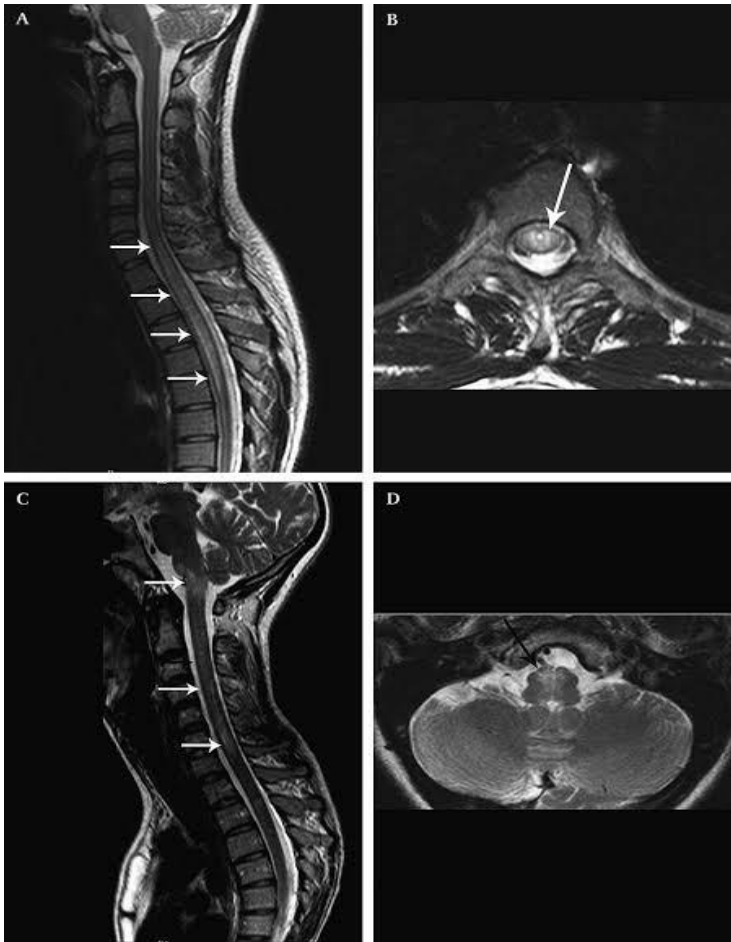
(A) Sagittal T2-weighted MRI scan of cervicothoracic spinal cord showing longitudinally extensive myelitis in a case of neuromyelitis optica (NMO). Note that the lesion spans six vertebral segments with cord expansion. (B) Axial T2-weighted MRI scan (corresponding axial image of (A)) showing the transverse extent of the lesion, which involves more than half of the cord. (C) Sagittal T2-weighted spinal MRI scan of another patient with NMO showing a medullary lesion in contiguity with cervical myelitis. (D) Axial T2-weighted MRI scan (corresponding axial image of (C)) showing the medullary lesion. White and black arrows point to the intrinsic lesions. Adapted from [80](#).
